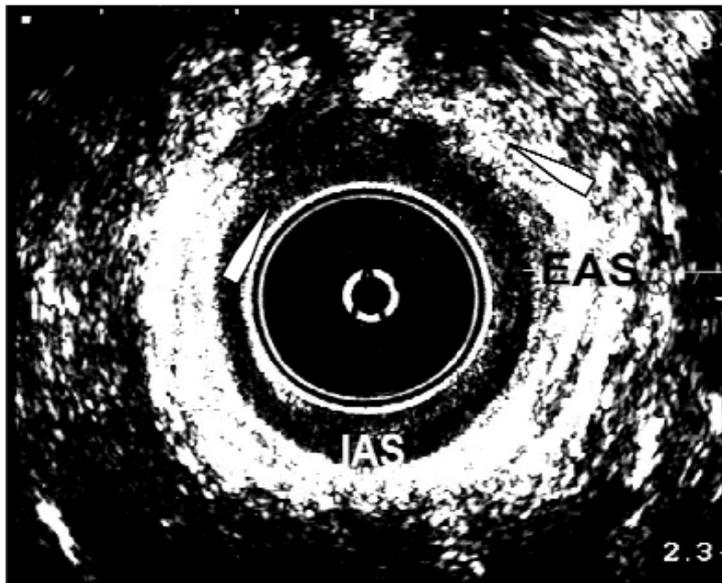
Anal ultrasound image of the mid anal canal. EAS = external anal sphincter. IAS = internal anal sphincter. The area between the arrows at 10 and 1 o'clock represents an external anal sphincter defect
